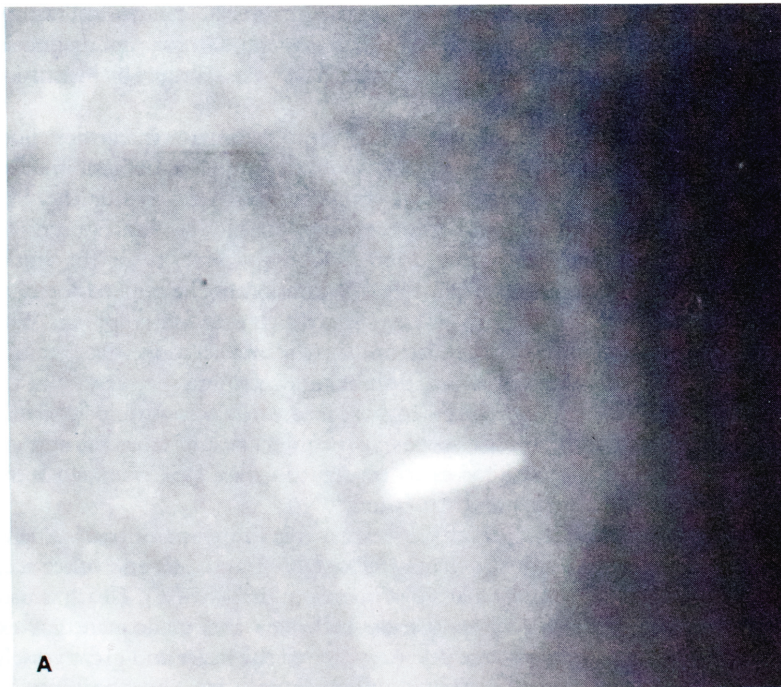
(A) Chest x-ray film from a patient with a history of a stab wound to the chest shows the presence of a foreign body. (B) The resected foreign body was the tip of a knife.
